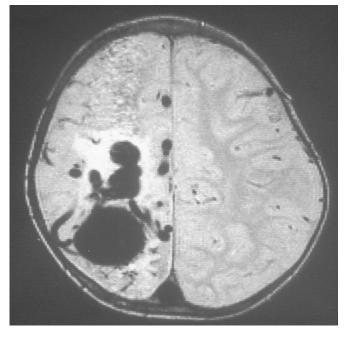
Brain MRI showing CAVM in 9-month-old patient.
